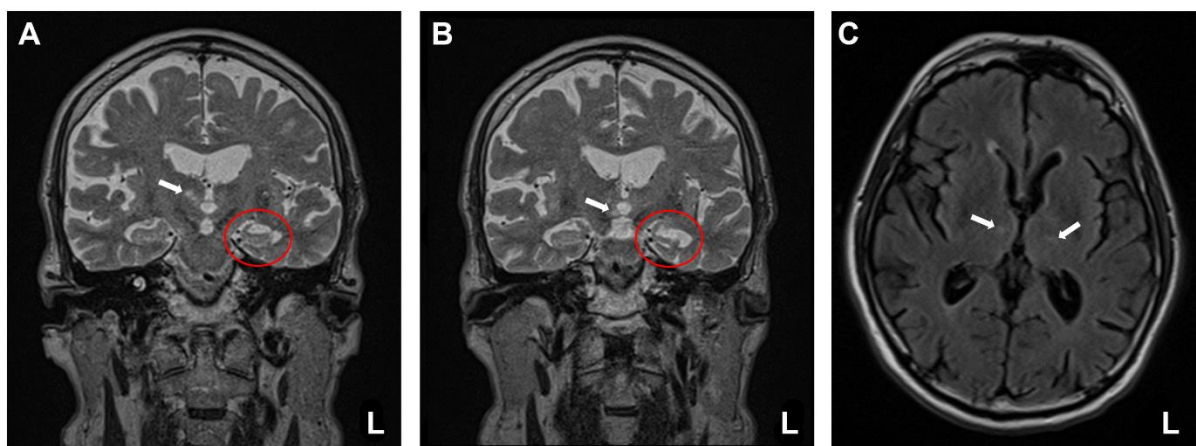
Panels A and B are T2-weighted coronal scans showing the shrunken hippocampus in the left hemisphere (highlighted by the red circle). Panel A additionally shows a subacute thalamic infarct in the right hemisphere and Panel B shows a right-hemisphere infarct at the level of the mammillary body (indicated by the white arrows). Panel C is a FLAIR scan showing the right-sided thalamic infarct and possibly a second infarct in a near-identical position in the left hemisphere (indicated by the white arrows). In all images the left hemisphere is shown on the right.
